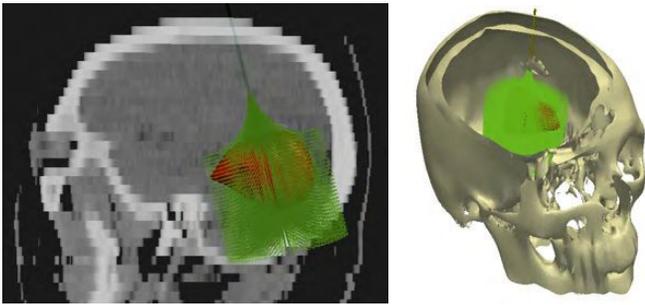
Example patient case. Left: Sagittal CT slice view with 3D model of the hematoma (red). The active cannula approaches the hematoma through a straight access path and the achievable workspace is visualized (green). Right: The workspace of the active cannula covers the hematoma.
